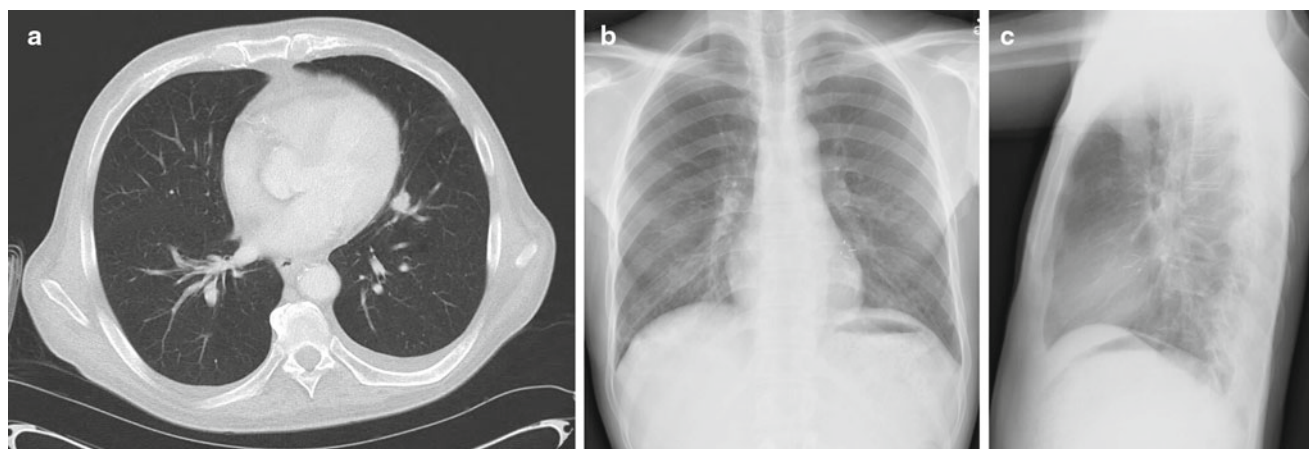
Recommended placement of fiducial markers near a small left sided tumor. *Panel A* shows a cross sectional CT image of the target tumor. *Panel B* and *C* show a posterior-anterior and lateral chest X-ray of the target tumor following implantation of four 0.75 mm diameter coiled wire fiducials in and around the tumor. Note that the fiducials are
